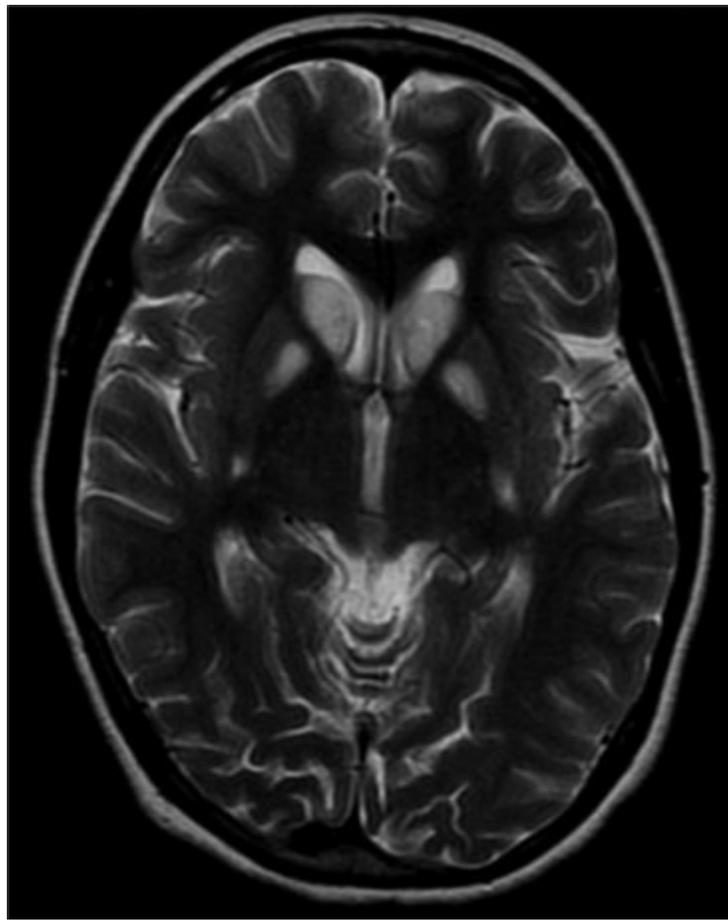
T2-weighted MRI in an 8-year-old girl with MERRF demonstrating bilateral signal hyperintensities of the caudate nuclei.
